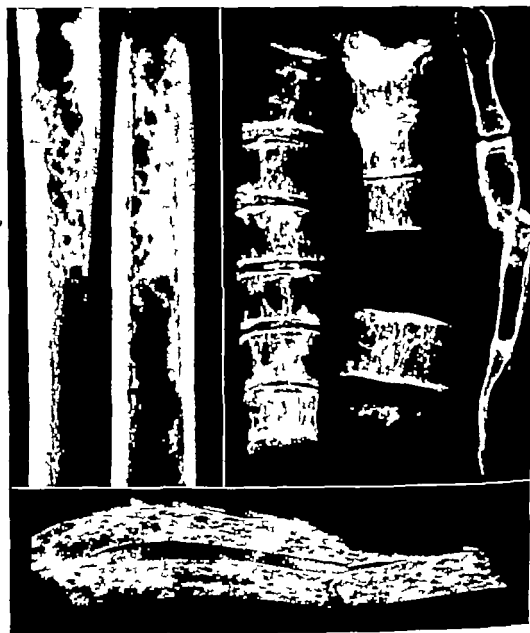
Roentgenograms showing the skeletal changes observed at autopsy in a far-advanced case of multiple myeloma. *A* In the shaft of the femur. *B* In the vertebral column and in the sternum, the body of which shows a previous pathologic fracture. *C* In the ribs, which are reduced to thin shells honeycombed by myeloma.
